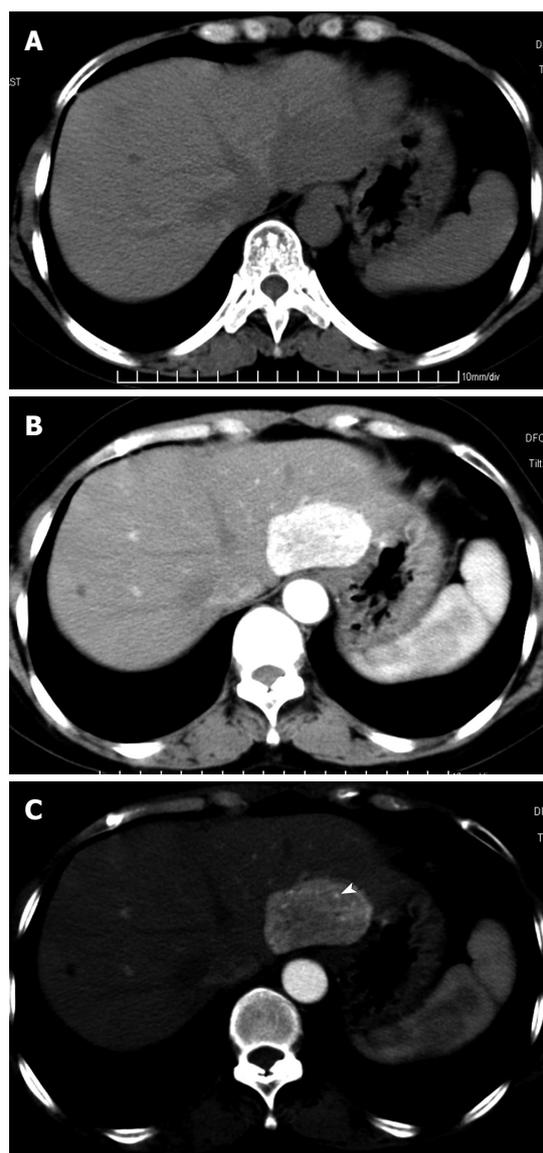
55-year-old woman with epithelioid angiomyolipoma in left lobe of liver (patient 6). A: Non-enhanced CT scan shows hypoattenuating lesion in segment II; B: contrast-enhanced CT scan shows obviously enhanced lesion on arterial phase; C: the punctate enhanced vessels (arrowhead) within the lesion is show on an arterial phase image by adjusting the window width and level.
